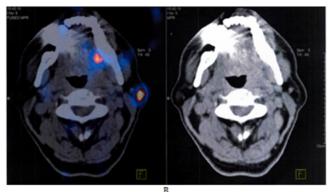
Exemple of preoperative imaging of SPECT-CT highlighting the nodes mapping.A) exemple of 3D reconstruction. B) exemple of SPECT-CT slides.
